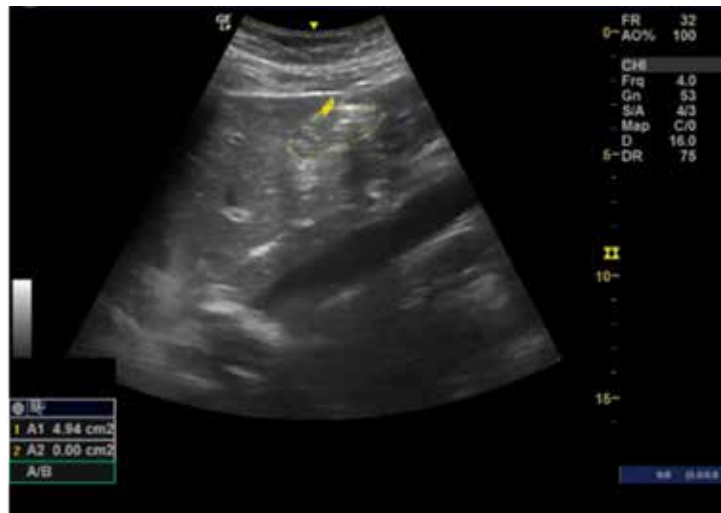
Ultrasonographic image of the gastric antrum showing an area of 4.94 cm<sup>2</sup> with the patient in the right lateral decubitus position.
